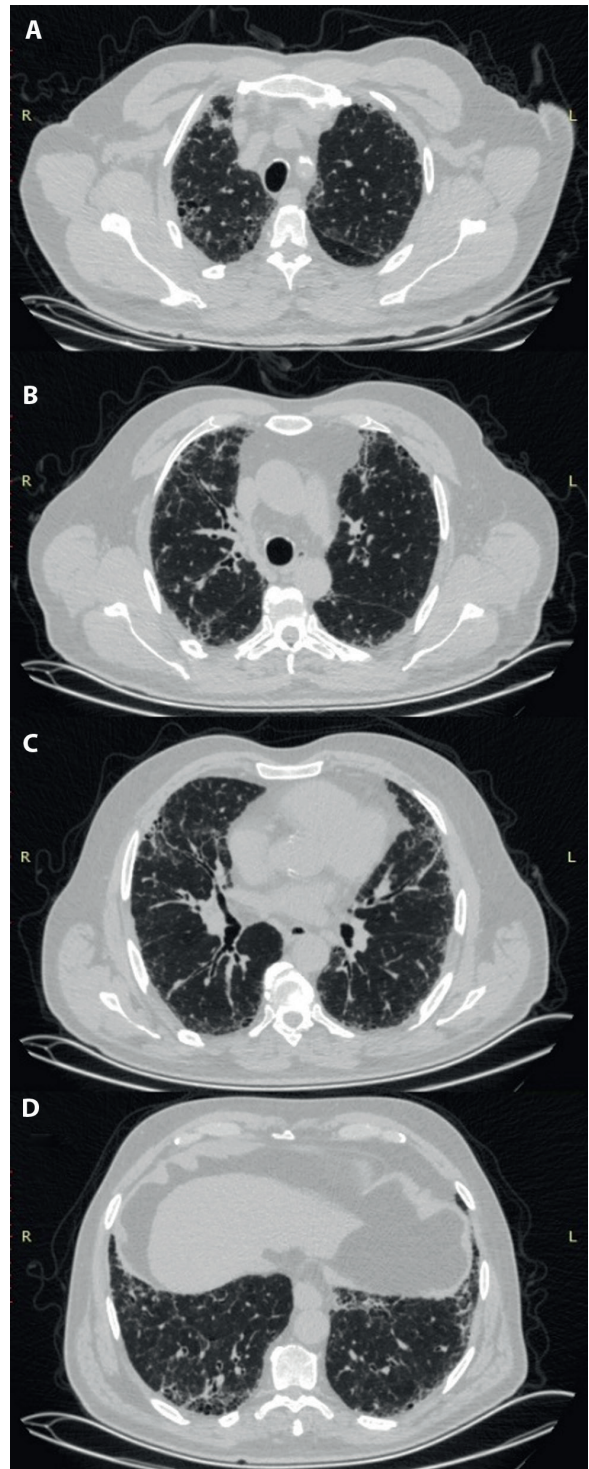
Figure 1A, 1B, 1C, 1D. Chest high-resolution CT imaging of Case 1 showing diffuse bilateral ground glass patchy opacities, mosaic pattern, minimal air-trapping, traction bronchiectasis, minimal honeycombing and reticulations.
